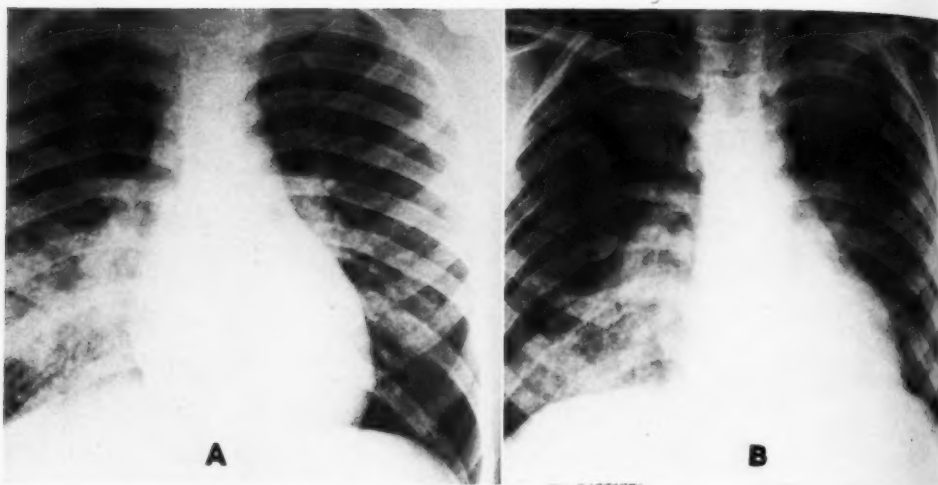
Acute pneumonia seven days after the onset. A. Roentgenogram with normal pressure. B. Roentgenogram with high pressure. With normal pressure (A), there is a pneumonic opacity in the right lower lobe. With high pressure (B), the opacity is still shown but it is more distinct and more clearly outlined.
